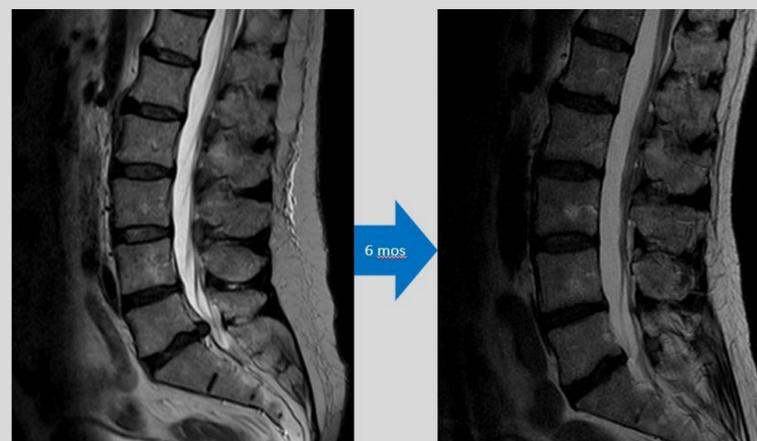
Sagittal T2-weighted MRI demonstrating initial L5-S1 disc extrusion at presentation followed by resolution.
